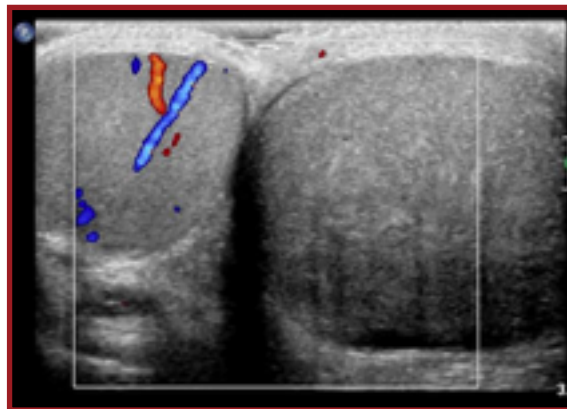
Scrotal ultrasound depicting lack of arterial or venous flow in testicle, consistent with testicular torsion
